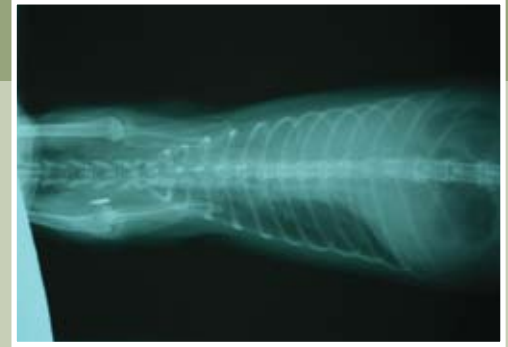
Radiograph showing consolidated lung tissue.
